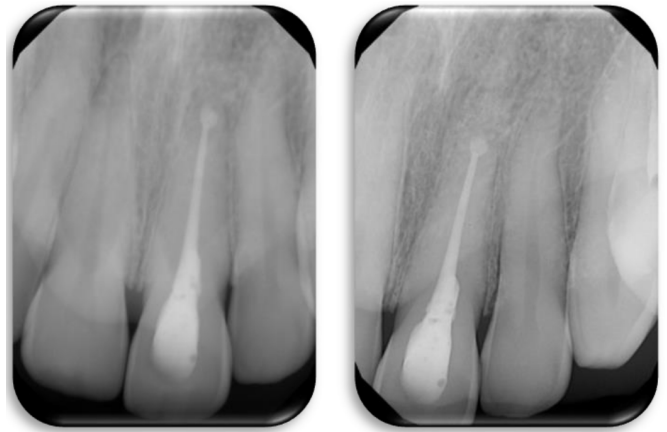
(Left): post root canal treatment periapical radiograph- Figure 2B (right) post-bleaching (4 months) radiograph
